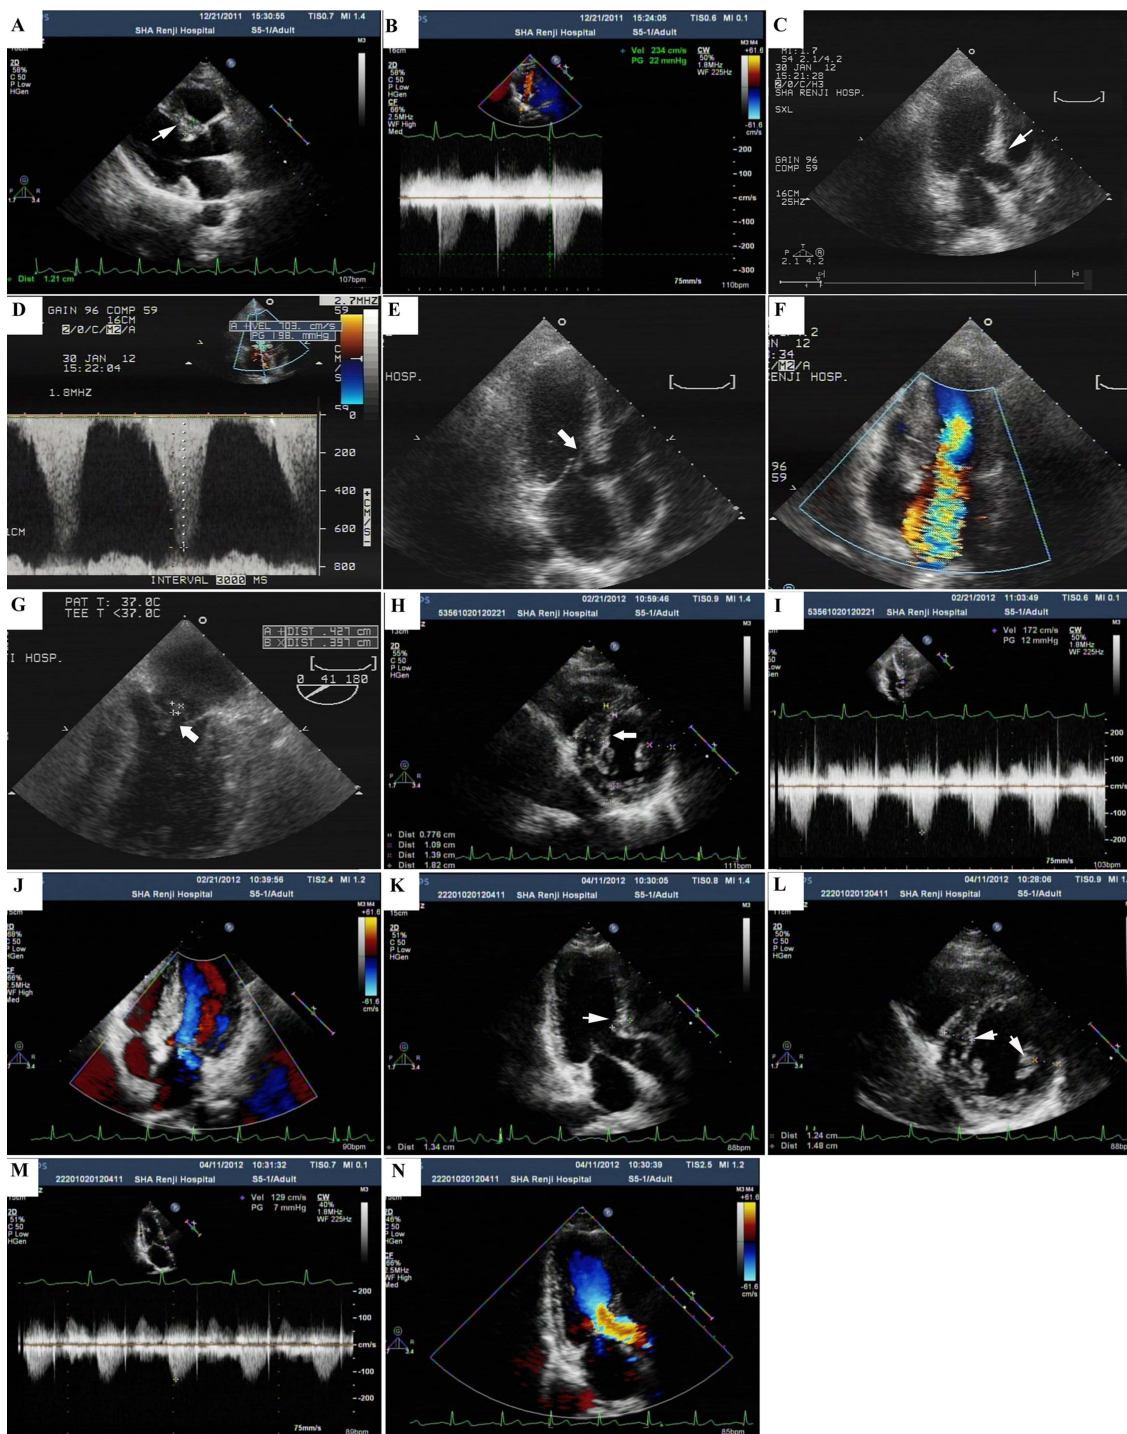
Echocardiographic findings of the patient with systemic lupus erythematosus during the course of prednisone treatment. (A and B) An apical four-chamber view showed a thickening of the anterior septum at the base level (white arrow) before the flushing dose of prednisone. Continuous-wave Doppler showed that the velocity in the left ventricular outlet was 234 cm/s (22 mm Hg). (C–G) The thickness of the anterior septum increased to 12.7 mm in the apical three-chamber view, and the velocity in the left ventricular outlet increased to 703 cm/s (198 mm Hg). There was a significant systolic anterior motion (white arrow) in the apical three-chamber view. Severe mitral regurgitations and excrescence-like mitral prolapse (arrow) were detected after the dose of prednisone was increased to 120 mg/day for 3 days. (H–J) After the dose of prednisone decreased to 15 mg/day, the thickness of the posterior septum increased to 18 mm, but the velocity in the left ventricular outlet decreased to 172 cm/s. The systolic anterior motion and mitral prolapse disappeared; only mild mitral regurgitation was observed (J). (K–N) After 50 days of follow-up, the thickness of the septum decreased gradually under the maintained prednisone dose. Only mild mitral regurgitation was observed. The velocity in the left ventricular outlet remained normal.
